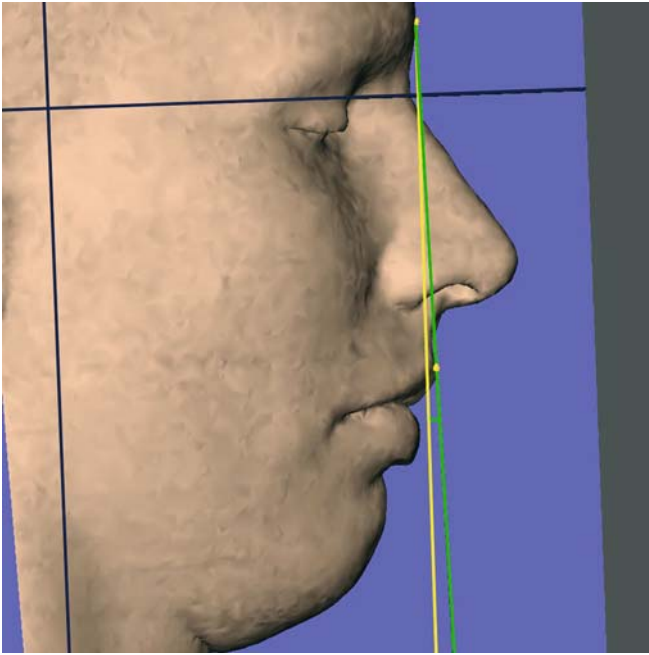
The inclination of the Leiber line from the vertical plane, $g-ls / y$ -plane, is a projected angular soft tissue measurement on the median (z) 3-D cephalometric reference plane (3-D CT, soft tissues, patient K.C.)
